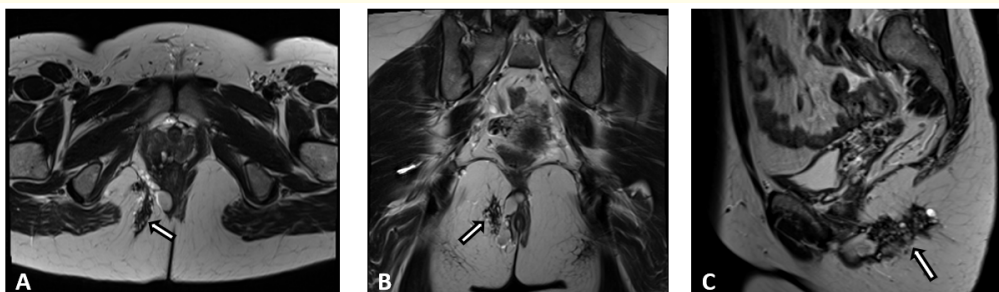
MRI Pelvis:T2 Weighted Images (A) Axial, (B) Coronal and (C) Sagittal: Shows extensive speckled fibrotic tissue in the fat planes of the right ischioanal fossa along the lateral aspect of the external anal sphincter (12-7 o'clock positions) (arrows), presumptively related to the previous episiotomy scar as reviewed in the clinical data.
